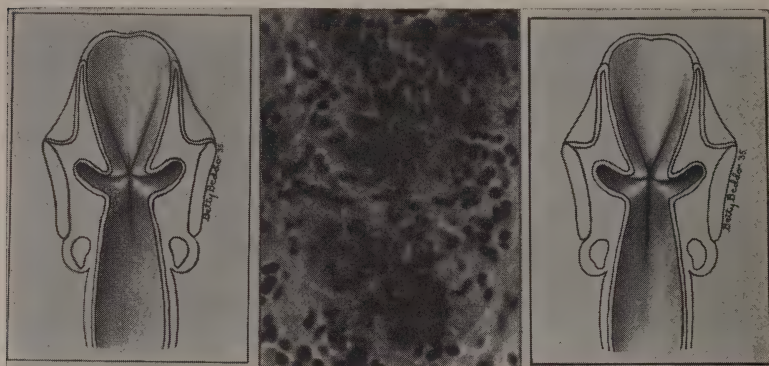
Early epidermoid carcinoma of the vocal cord treated with deep x-rays by delivering 4,250 r to the sides of the neck during a period of twenty-one days. Two months later after the reaction had disappeared the laryngologist reported only a slight scarring which the artist failed to indicate in the sketch on the right.
